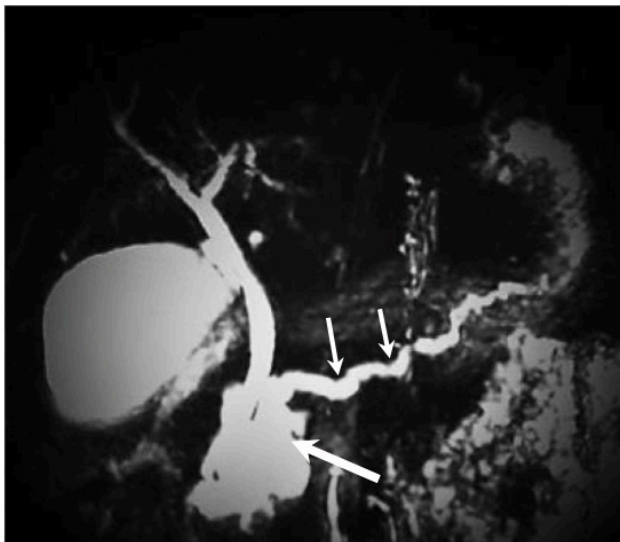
Coronal view of T2-weighted MRCP of the pancreaticobiliary tree indicating high intensity ill-defined multiloculated cystic lesion in the uncinate process region (large arrow) which communicates with the MPD. Dilatation of MPD (small arrows) is clearly visible.
